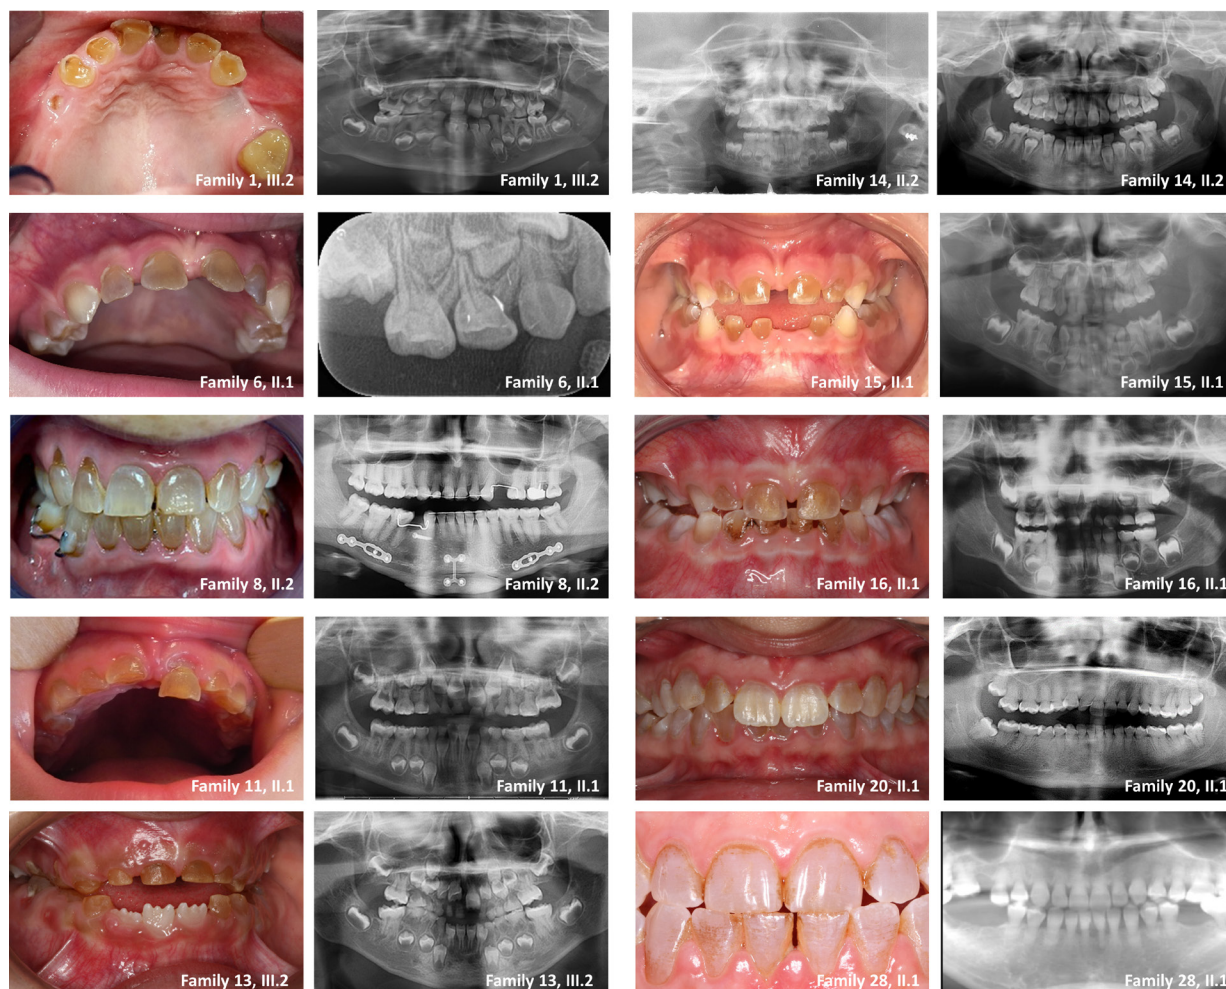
Dental phenotype in patients carrying dentin sialophosphoprotein variants. Both permanent and primary dentition of probands display the hallmarks of DI, with transparent amber-brown discolouration of the dentin, enamel loss and excessive tooth attrition. Clinical variability is observed among families. Panoramic radiographs show obliterated pulp and root canals, with absence of the pulp chamber. The roots appear short and narrow, and a bulbous-shaped crown with a marked cervical constriction is observed. Families 6, 14 and 15 exhibit clinical features of dentin dysplasia, presenting a similar phenotype to DI in primary teeth, while the permanent dentition appears nearly normal but shows deformity of the pulp chambers and pulp stones on radiographic examination. Families are displayed in ascending order according to the location of the pathogenic variant (see online supplemental table S4). DI, dentinogenesis imperfecta.
